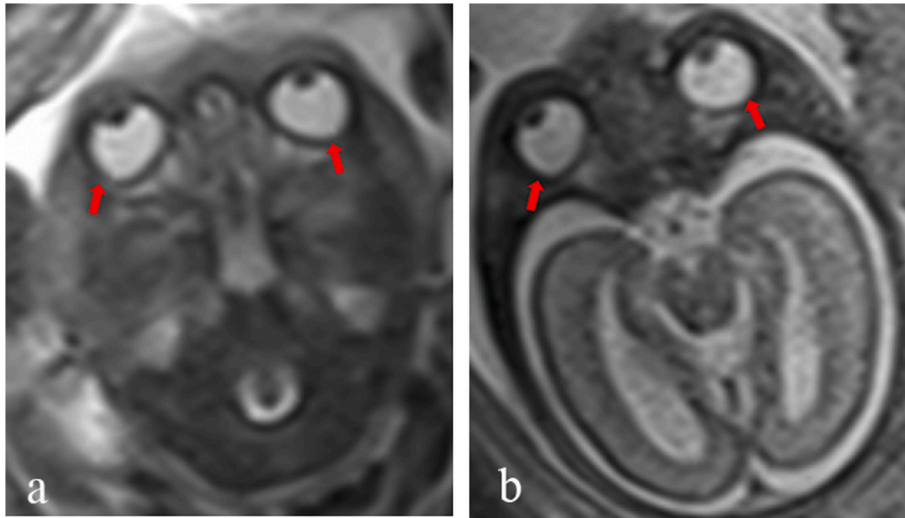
T2-HASTE MR imaging (TR/TE, 1350 ms/92 ms); the ocular morphology of a normal fetal brain on axial section from this study at (a) 23 and (b) 26 weeks' gestation in two patients, respectively. Note: The globe morphology is conical, with angulation of its posterolateral (red arrows) margins. (For interpretation of the references to colour in this figure legend, the reader is referred to the Web version of this article.)
